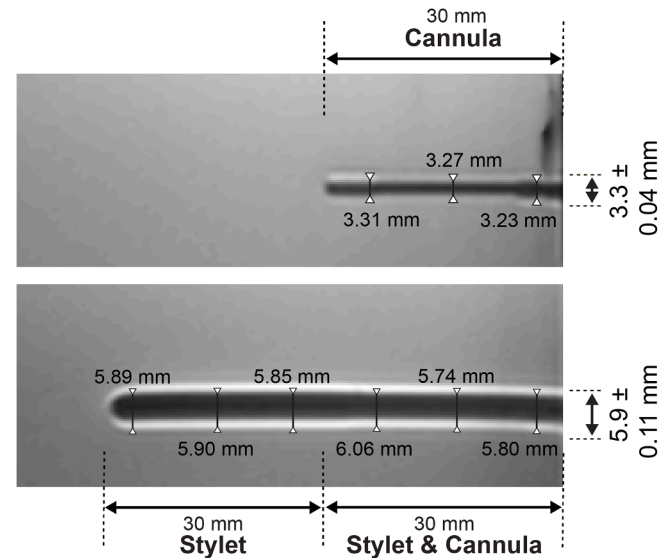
Artefact visualization and measurements on MRI scan of the cannula (top), stylet (bottom left) and stylet and cannula together (bottom right) in perpendicular orientation towards B0.
